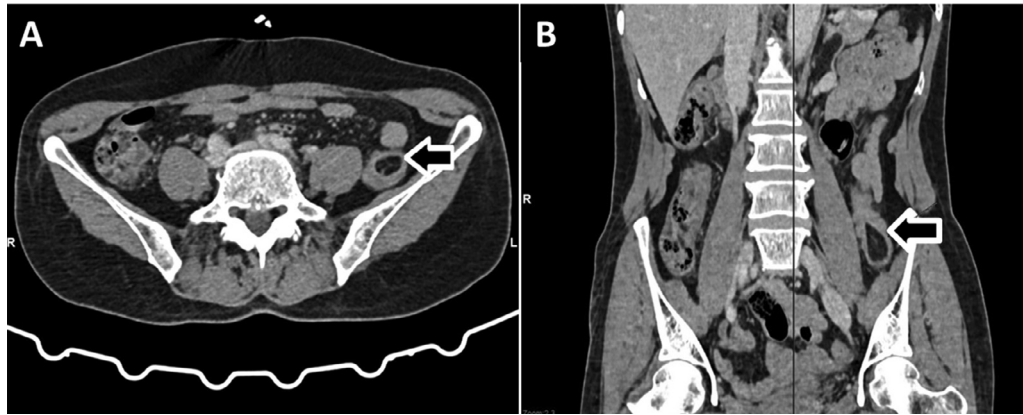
Images of a lipoma (arrow) of the descending colon on a computed tomography scan: (A) Axial plane and (B) Coronal plane.
